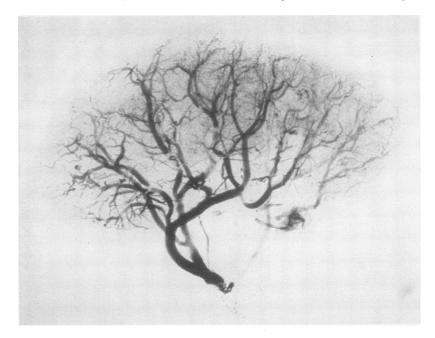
ROENTGENOGRAM OF THE ARTERIAL TREE IN A SEVERELY CONTRACTED KIDNEY (ADVANCED ARTERIOLARSCLEROSIS) WHICH GAVE A GREATLY REDUCED PERFUSION FLOW (EXPERIMENT 46)
